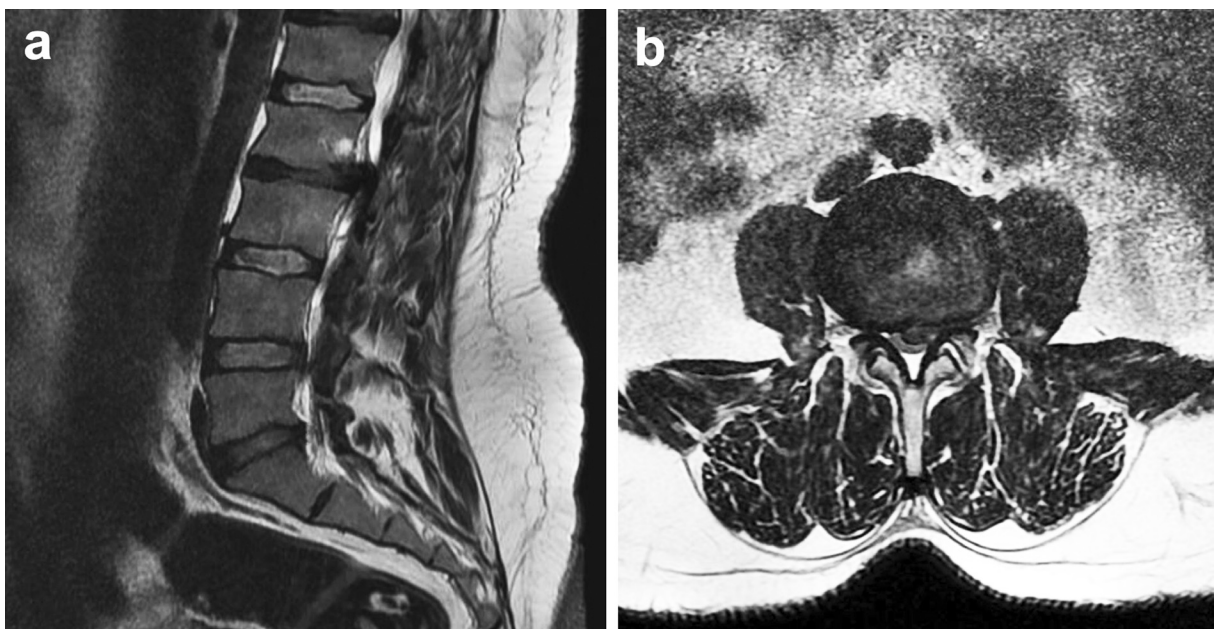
(a) Sagittal T2W and (b) Axial T2W Lomber MRI scans showing left-central disc herniation at L2-3 disc space of vertebra.
